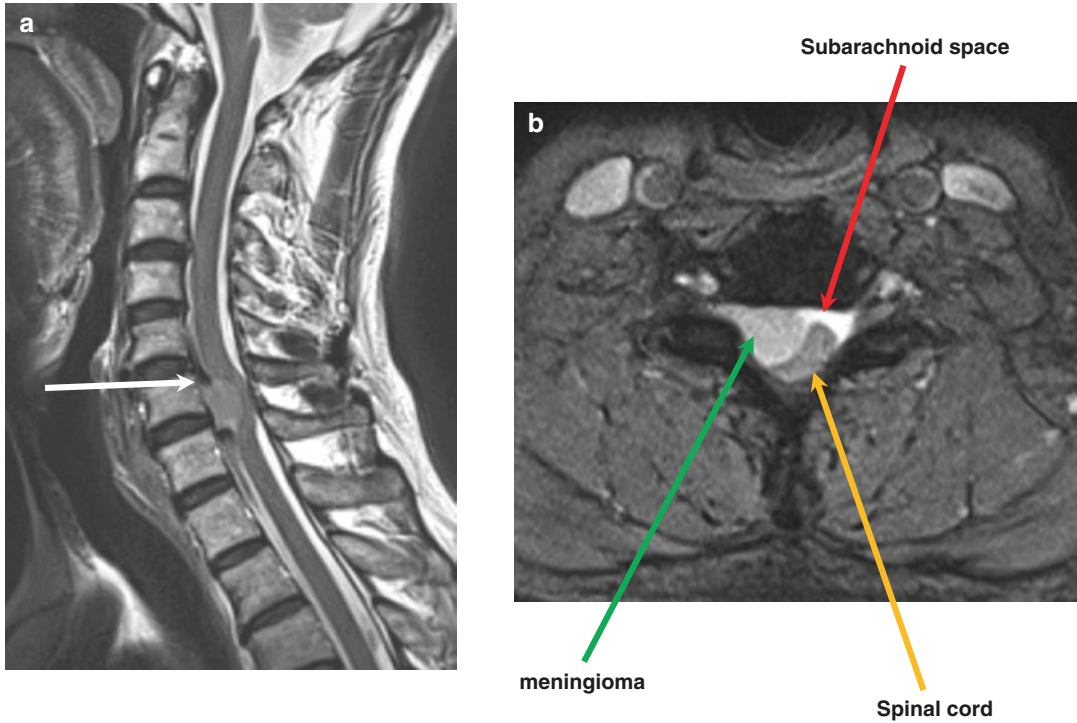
An approximately 1.5 cm intradural extramedullary (IDEM) mass at C6–C7 spinal level in a 63-year-old female. (a) The sagittal T2-weighted image shows a high signal intensity mass with “dural tail sign” (*white arrow*) combined with craniocaudal flow artifact. There is severe cord compression by the tumor. (b) On the axial T2-weighted MR image, there is left-sided cord deviation
